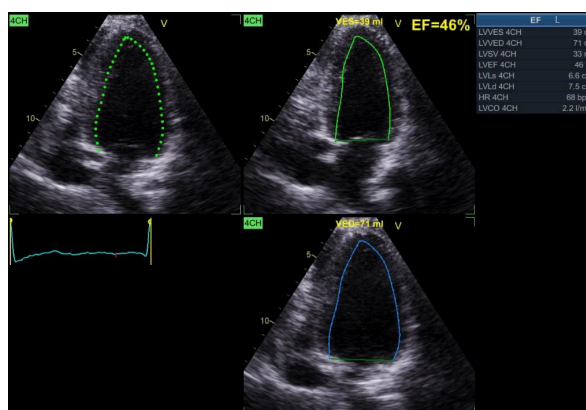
Apical four-chamber view showing no evidence of the previous thrombus.
